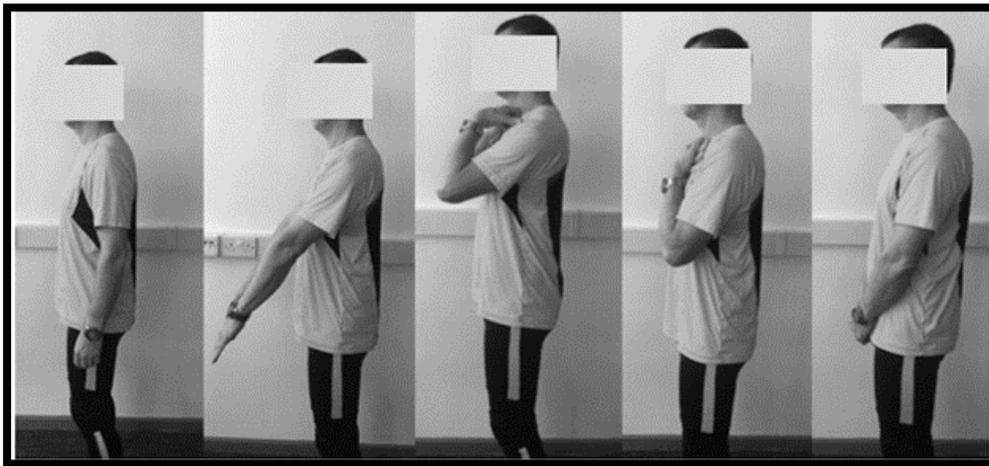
An example on four different erect positions examined in order to select an optimum position for erect lumbar spine radiography.
